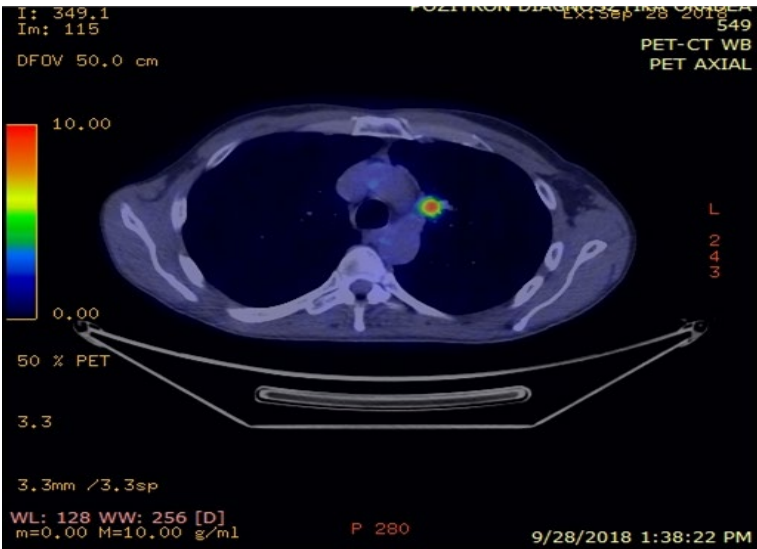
PET-CT: Para-aortic Nodule
